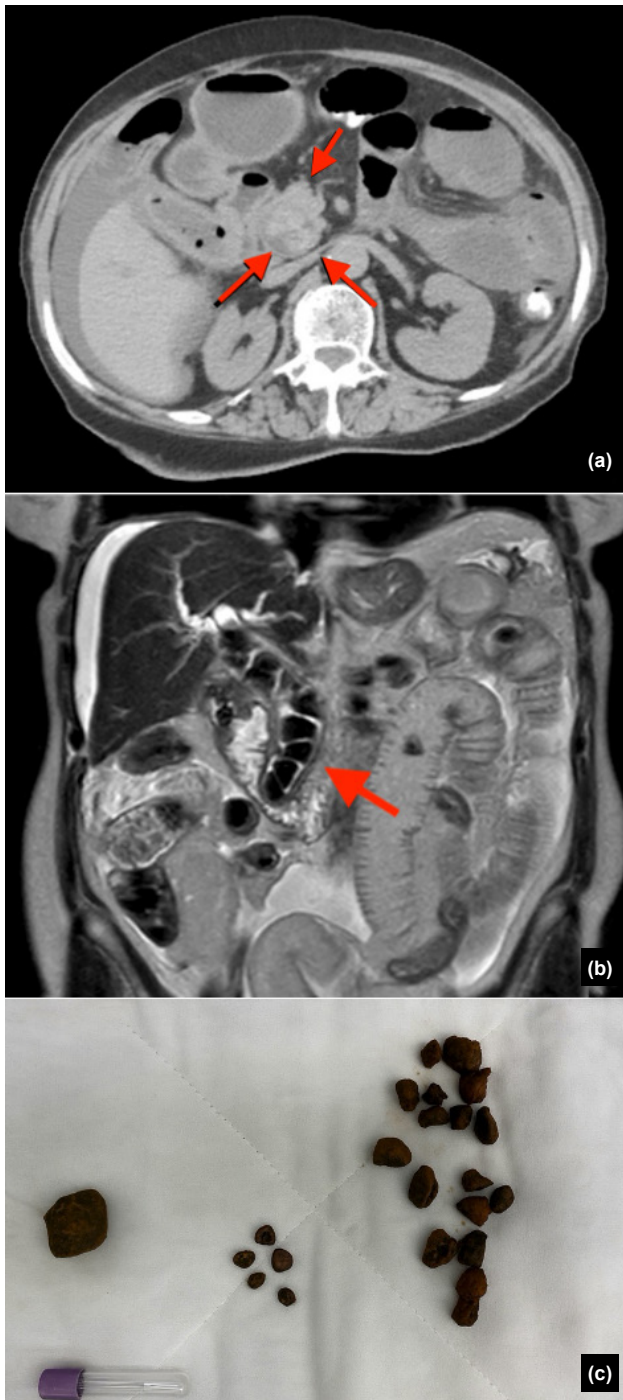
(a-c) Computed tomography (a) and magnetic resonance imaging (MRI) (b) images of a 67-year-old female patient with gallstone ileus. In addition to the obstructing gallstone within the bowel, multiple gallstones were identified in the common bile duct (CBD) (arrows). Therefore, cholecystectomy, fistula repair, and CBD exploration were performed. Gallstones extracted from the bowel, gallbladder, and CBD, shown from left to right, respectively (c).
